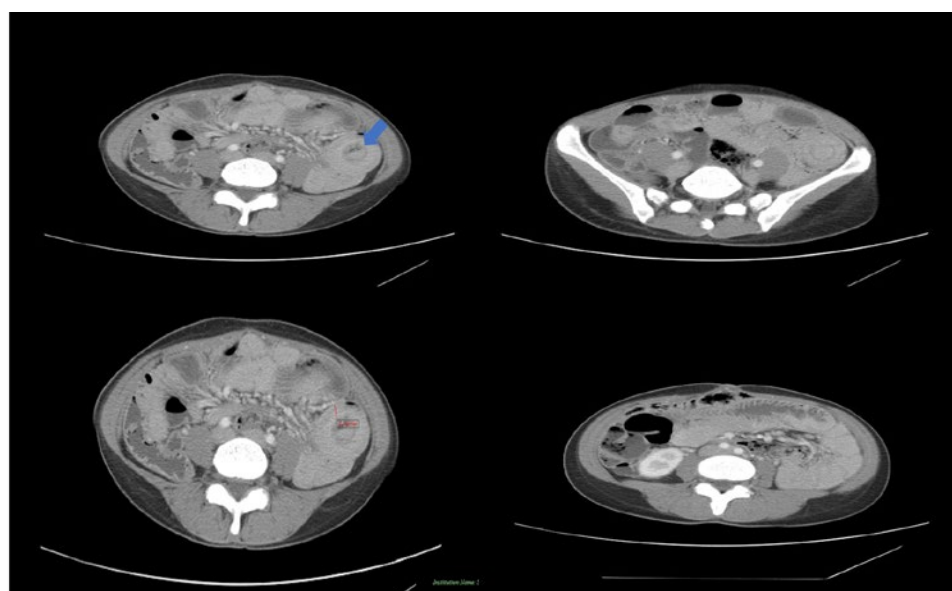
Abdominal and pelvic CT scan with intravenous contrast.
